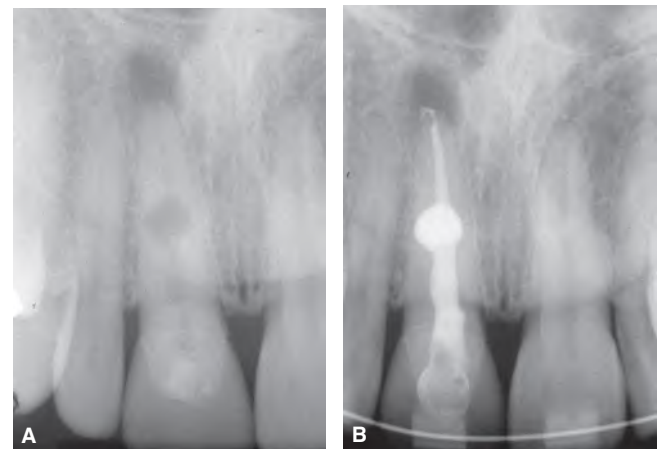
Teeth with internal root resorption can be treated successfully with any of the many endodontic techniques that allow filling material to be compacted into canal irregularities. A. Preoperative radiograph of a maxillary central incisor with internal resorption midroot. B. Radiograph after completion of the endodontic treatment procedure. (Courtesy of Dr. Steve Morrow, Loma Linda University, California.)
